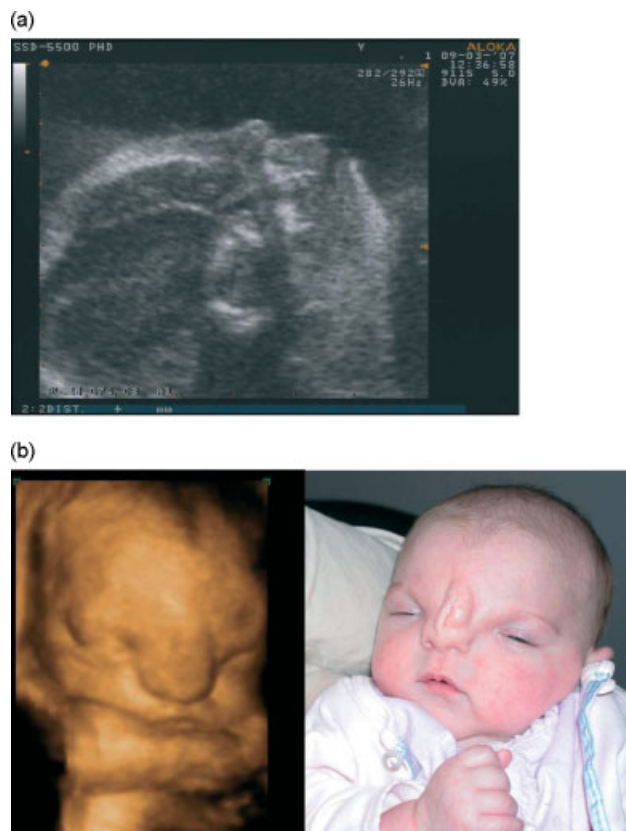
(a) Profile of foetus using 2D ultrasound at 20 weeks' gestation. (b) Foetal face image using 3D ultrasound and comparison of post-natal image of the infant
